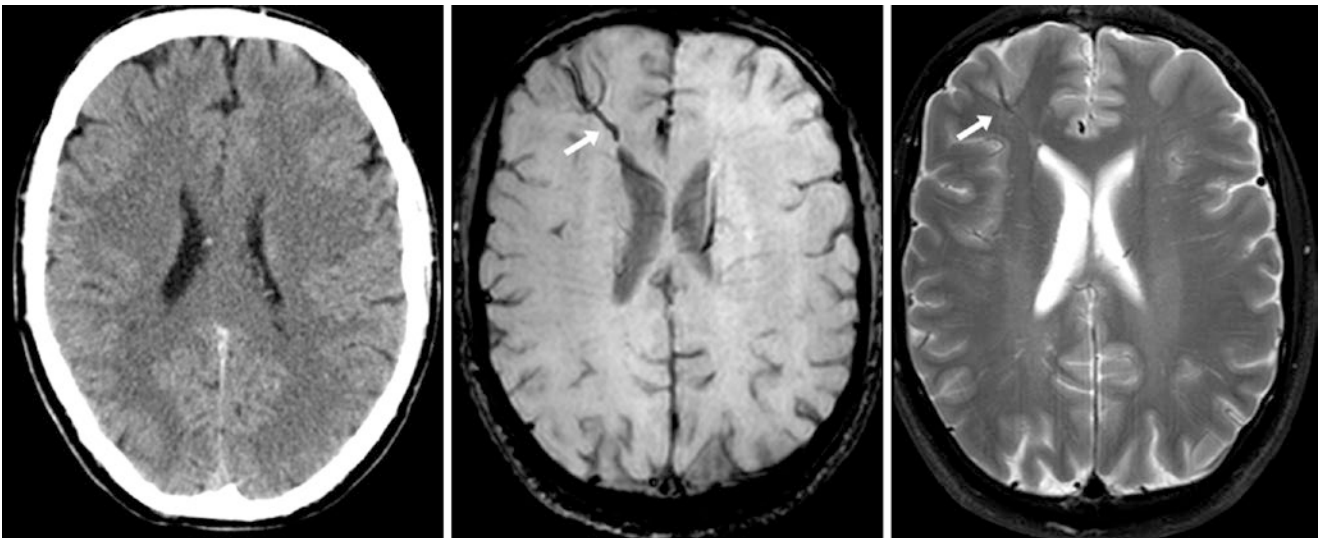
A 50 year old with psychosis in whom a NECT (*left*) was called negative, while a 3T MRI demonstrated a relatively large DVA (*arrows*) on SWI (*middle*). On T2WI (*right*), the vessels contributing to the DVA are barely visualized
